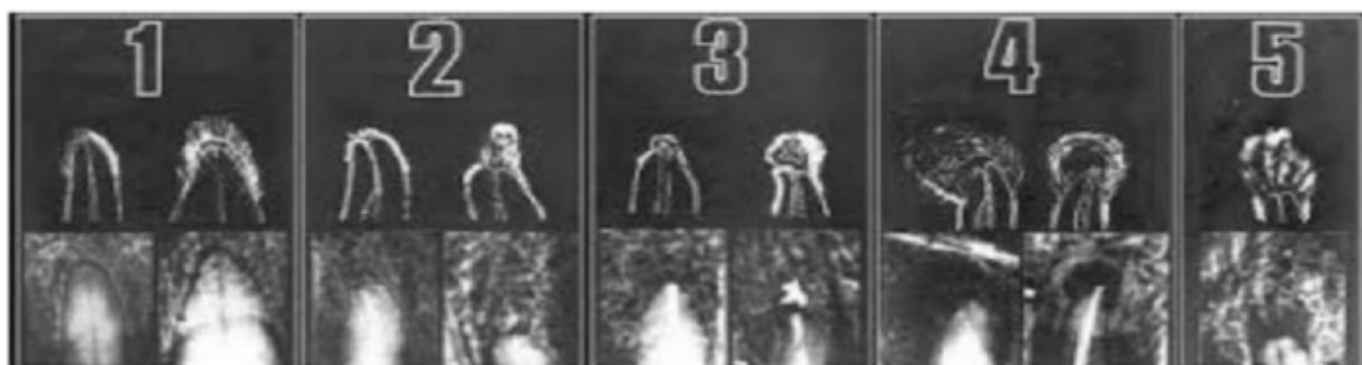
Periapical index (PAI) scores of apical periodontitis 32 based on the reference radiographs⁶
